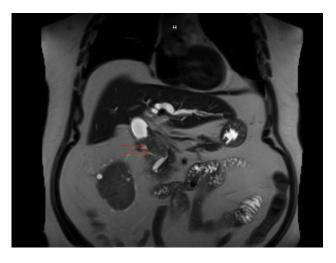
Initial magnetic resonance image from 2 years prior depicting lesion in bile duct.
